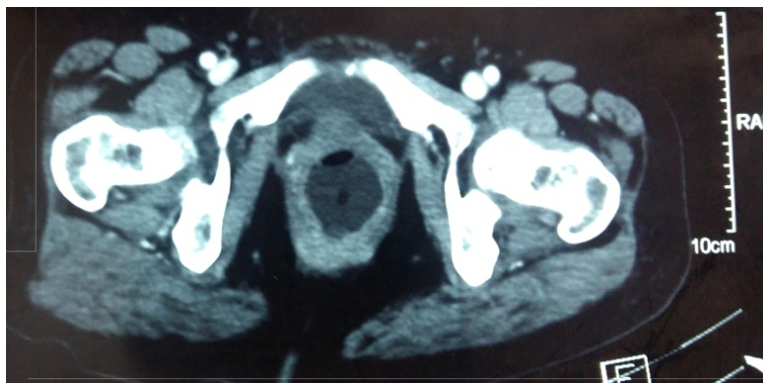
Contrast enhanced CT scan of the Pelvis showing eccentric wall thickening of the rectum
